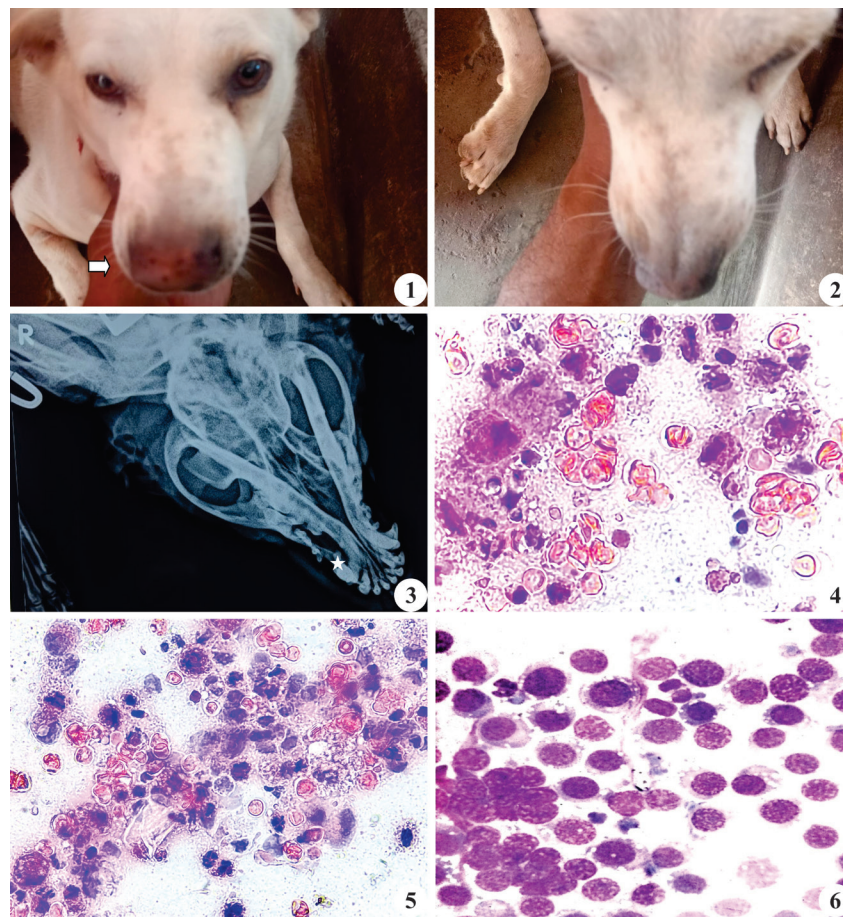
Swelling of nasal area on right side (arrow); Fig. 2. After complete remission of the mass; Fig. 3. Confirmation by radiographic examination showing presence of tumorous growth (contour marked with star) on right side of nasal cavity; Fig. 4. Cytology revealing numerous large round cells with large nucleus and small cytoplasmic rim with vacuolations (Giemsa 100x); Fig. 5. Increased cellularity with neutrophilic infiltration and increased nucleocytoplasmic ratio (Giemsa 40x); Fig. 6. Presence of intracytoplasmic vacuolation: typical characteristic of TVT (Giemsa 100x).
